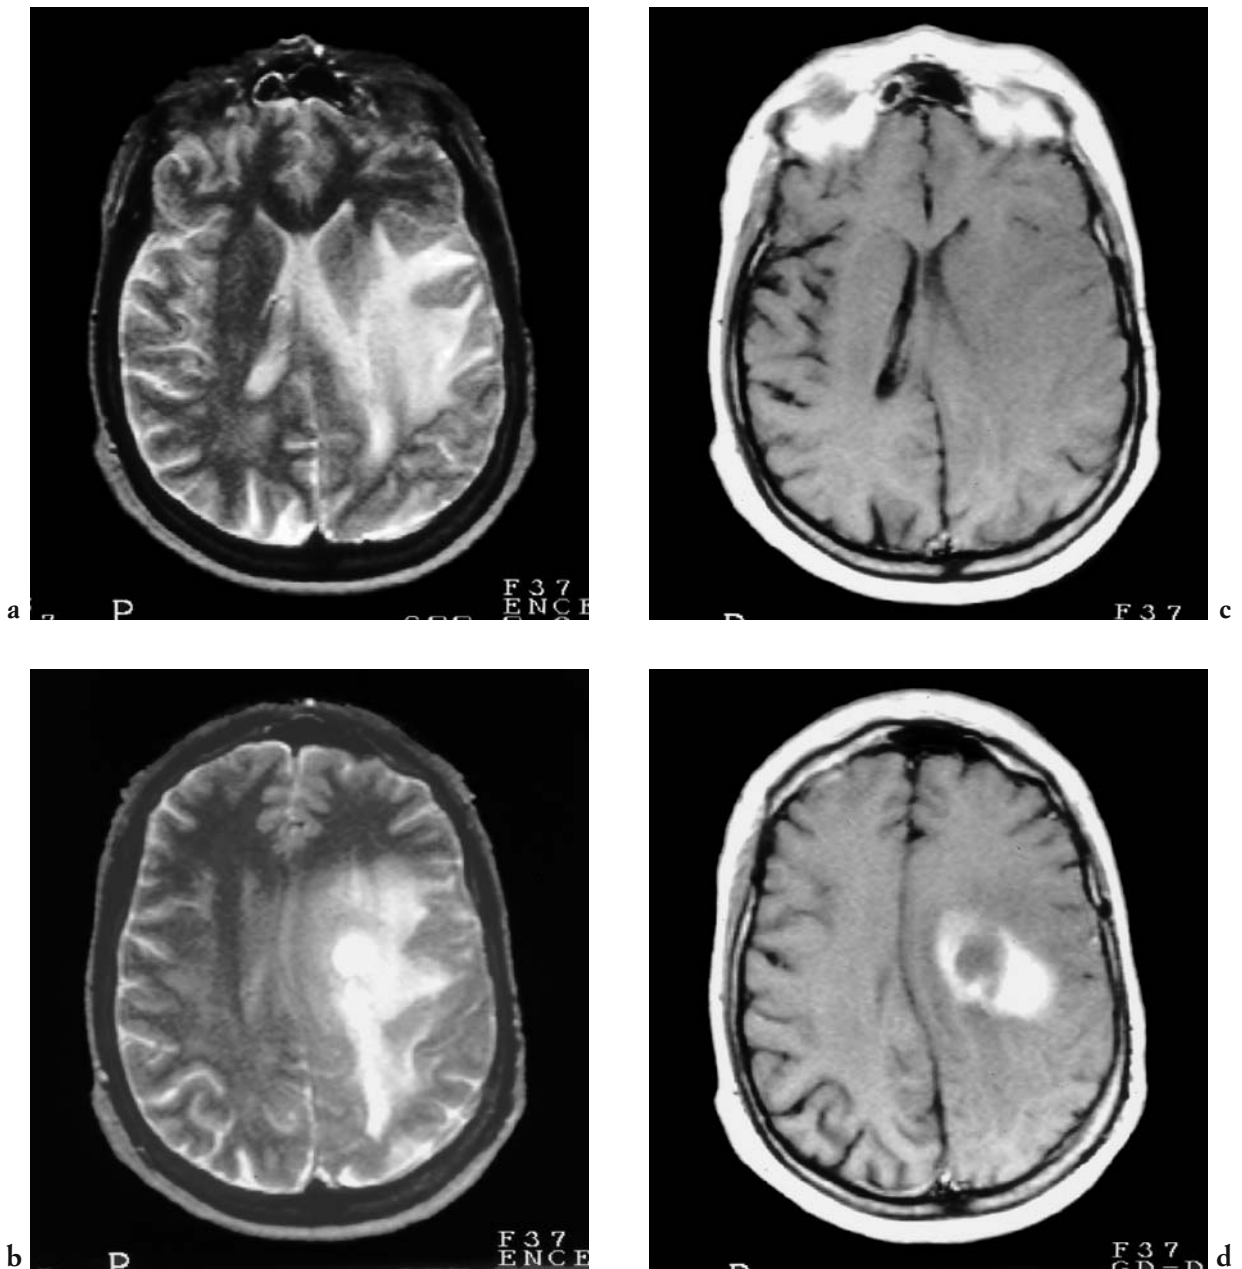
Vasogenic oedema caused by malignant cavitary glial neoplasm. The MRI study shows extensive oedema involving the white matter surrounding the neoplasm. Note the mass effect upon the lateral cerebral ventricles and the irregular mural contrast enhancement. [a, b) T2-weighted, c) unenhanced T1-weighted, d) and T1-weighted MRI following IV gadolinium (Gd) administration].
